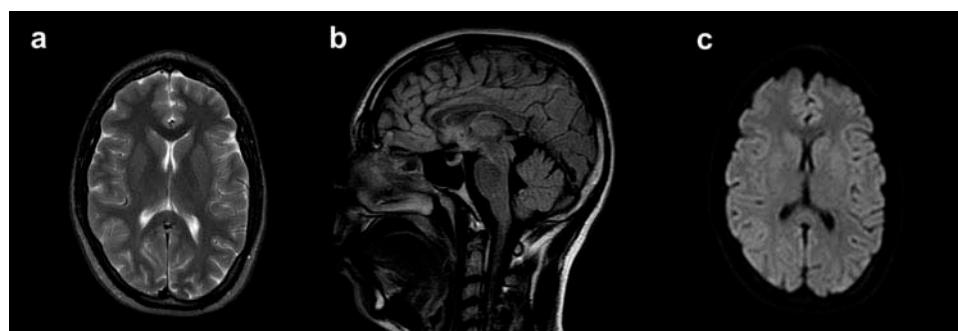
MRI scan performed at 1 month. (a, b) At axial T2 weighted and sagittal FLAIR images there was no more evidence of the lesion within SCC (c) Diffusion-weighted image did not show areas of hyperintense restricted diffusivity within SCC.
